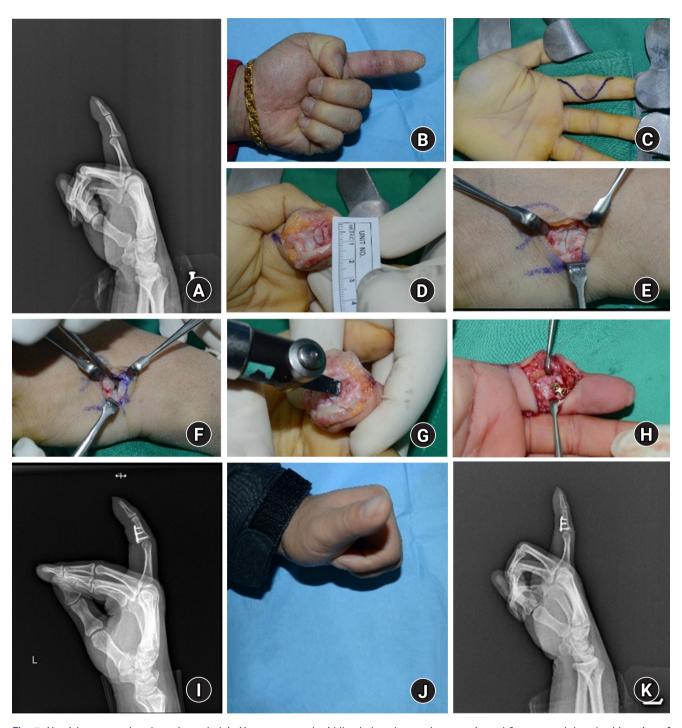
Hemi-hamate arthroplasty. Lateral plain X-ray presented middle phalanx base volar comminuted fracture and dorsal subluxation of joint (A). The patient complaint limited flexion in preoperative clinic (B). Volar Bruner incision was designed (C) and the fractured site was visualized with shot-gun approach (D). After fracture fragment measurement, dorsal hamate-metacarpal joint is approached for hemi-hamate harvest (E, F). With fractured proximal phalanx base preparation, the harvested hamate bone was grafted and fixed with small sized plate and screws (G, H). Post operatively harvested bone well fixed with implant without joint subluxation (I). On 8 months of post-operation, patient recovered full flexion without arthritic change (J, K). Case courtesy of SH Han from CHA University, Seongnam, Korea.
